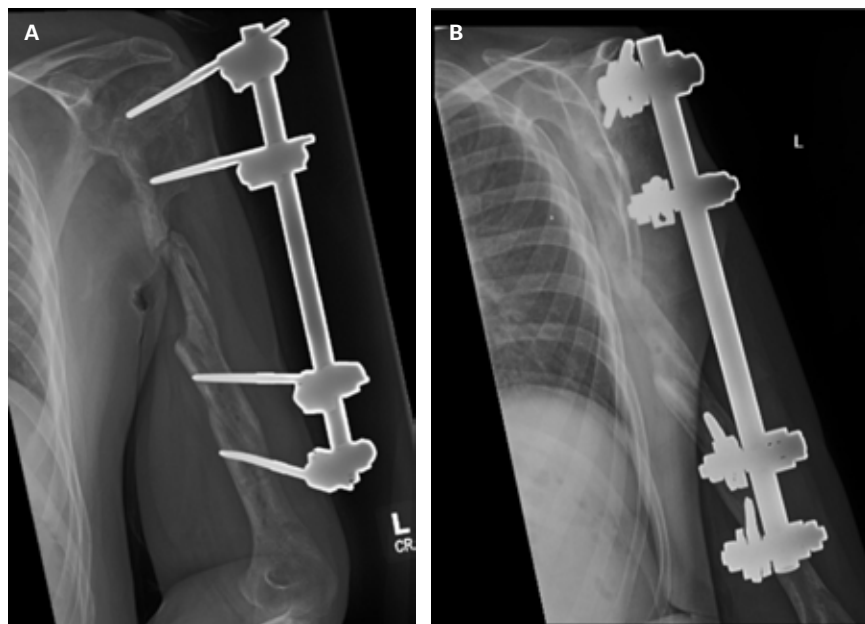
Left humerus x-rays. (A) AP (B) and lateral x-rays of the left humerus showing an external fixator in place. There is segmental bone loss and areas of persistent fracture lines along the midshaft of the humerus.
